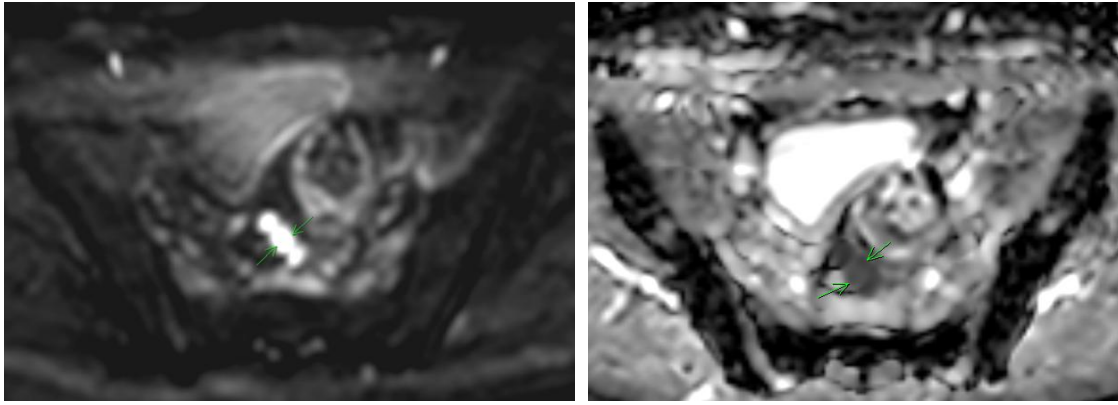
b,c: Corresponding DWI (b=800) and ADC map showing restricted diffusion within the recurrent lesion
